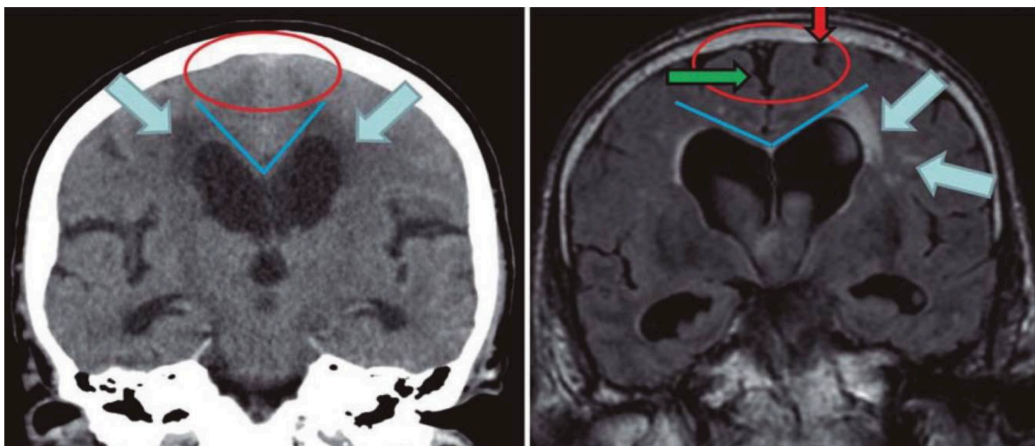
Coronal head CT (left) and MRI (right) at the level of the posterior commissure: in the left image, the CSF spaces over the convexity near the vertex are narrowed (red circle), as are the medial cisterns - these are typical findings of NPH. On the right image, however, the CSF spaces over the convexity near the vertex (red arrow) and the medial cisterns (green arrow) are widened, a finding consistent with brain atrophy. The blue lines in both images indicate the callosal angle: an angle less than 90° is typical of NPH (left image), while an angle greater than 90° is typical of brain atrophy (right image). The blue arrows indicate periventricular signal alterations; the unilateral occurrence of these alterations (right image) suggests they are probably due to vascular encephalopathy. The abnormalities seen in the left image may well represent transependymal CSF changes due to NPH. Reproduced from (Damasceno 2015) (In turn citing from (Kiefer & Unterberg 2012), with permission.
